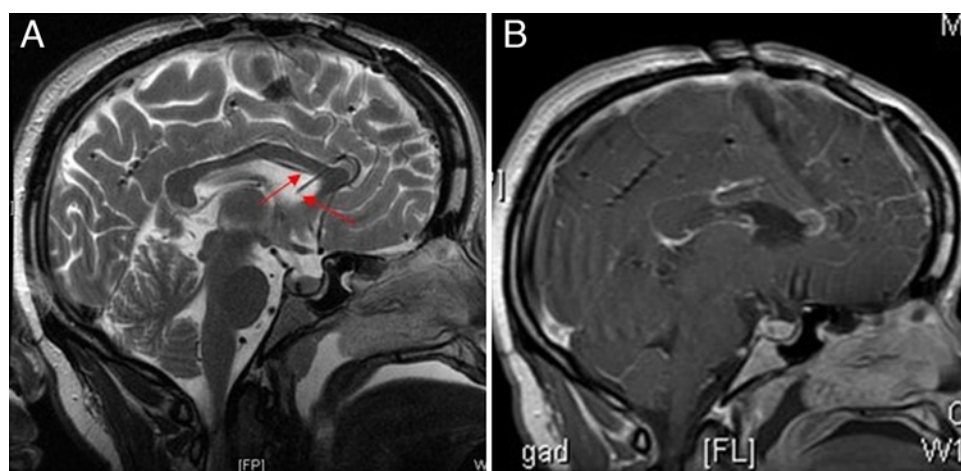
A: Sagittal intraoperative MRI study demonstrating misplaced fiber in case 1 (red arrows). B: Postprocedural T1-weighted MRI study obtained with contrast demonstrating incomplete callosotomy. Figure is available in color online only.
